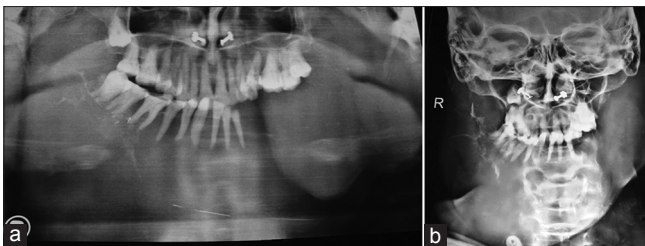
(a and b) Orthopantomogram and posteroanterior view showing an ill-defined, multilocular radiolucent lesion with massive cortical expansion and multiple displaced teeth ("floating teeth" appearance)
